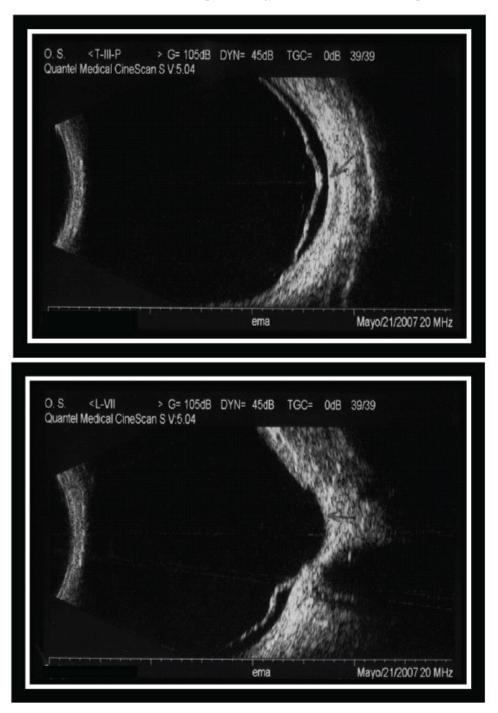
B-scan ultrasonography shows chorioretinal coloboma with associated retinal detachment.
